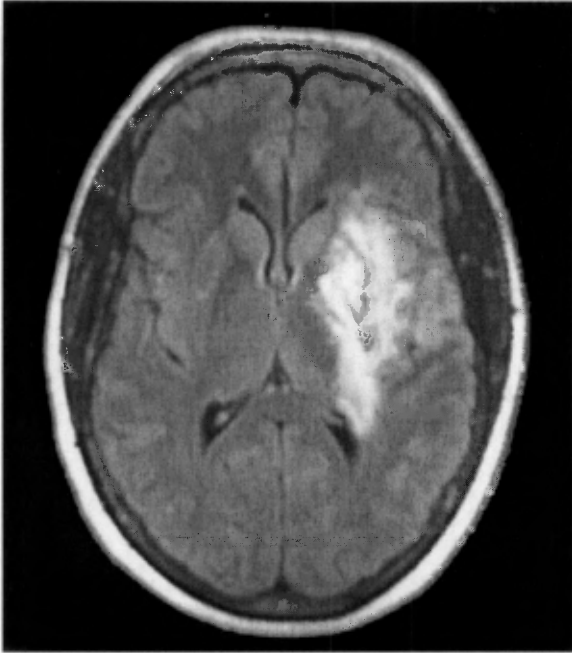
Case No. 5's CT Scan (Hyperintensity in the Basal Ganglia Excluding the Head of the Left Caudate Nucleus)
